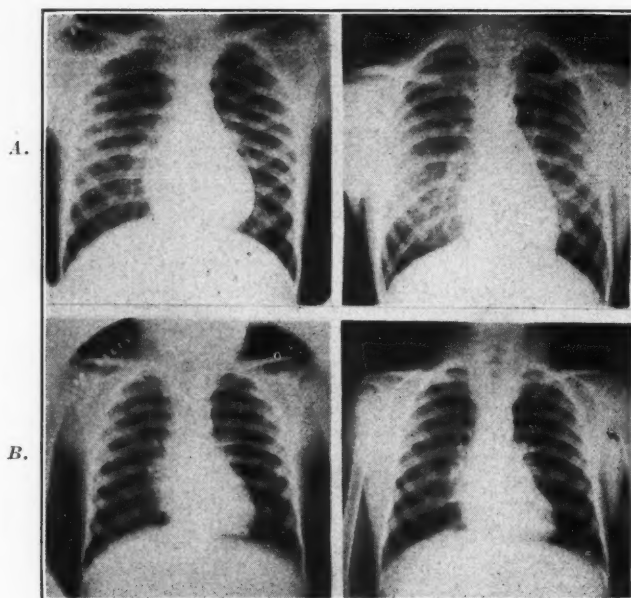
Chest roentgenograms of W. M. in supine (left) and upright positions, showing marked alteration in heart shape with change in posture. Note also relatively heavy "lung markings."
